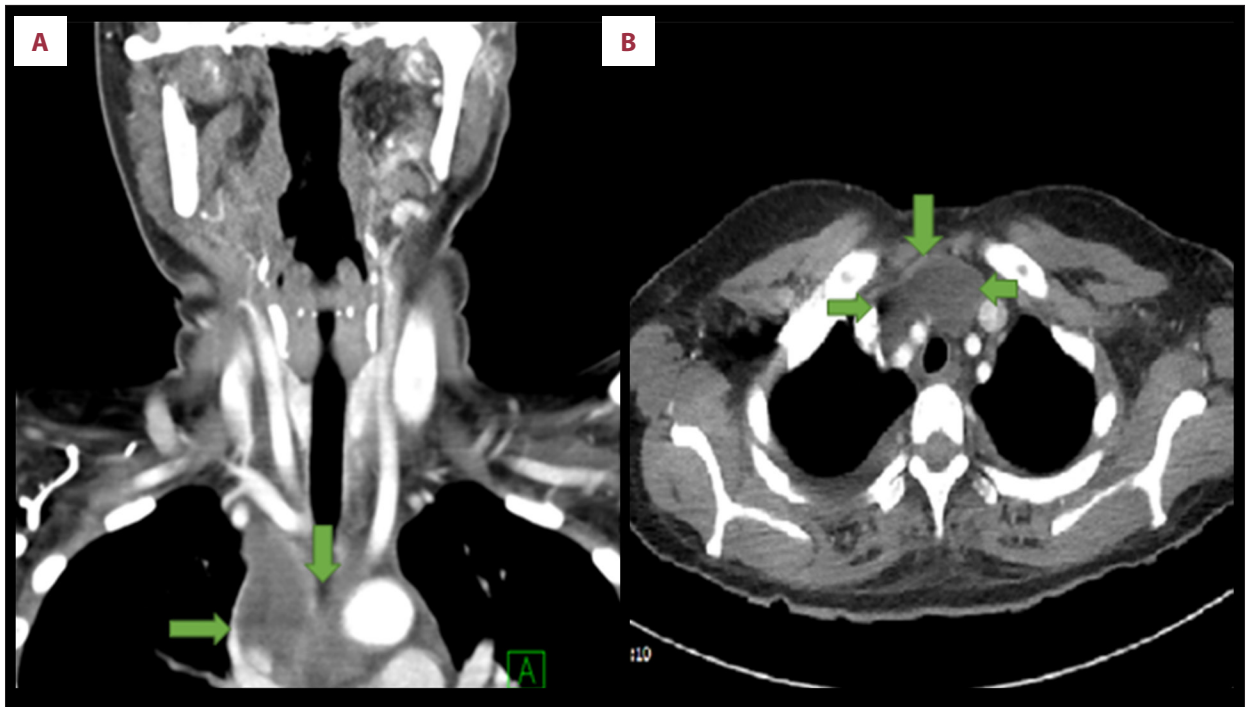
Computed tomography (CT) neck-thorax coronal (A) and axial (B) view. CT neck-thorax coronal (A) and axial (B) view showing septated peripherally enhancing anterior-superior mediastinal collection (green arrows).
